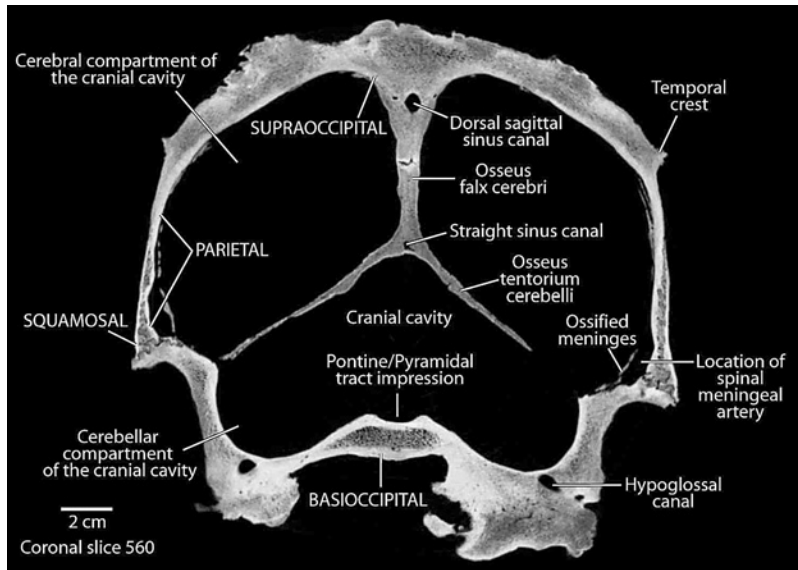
Coronal slice 560, a representative CT slice from the original scan data.
